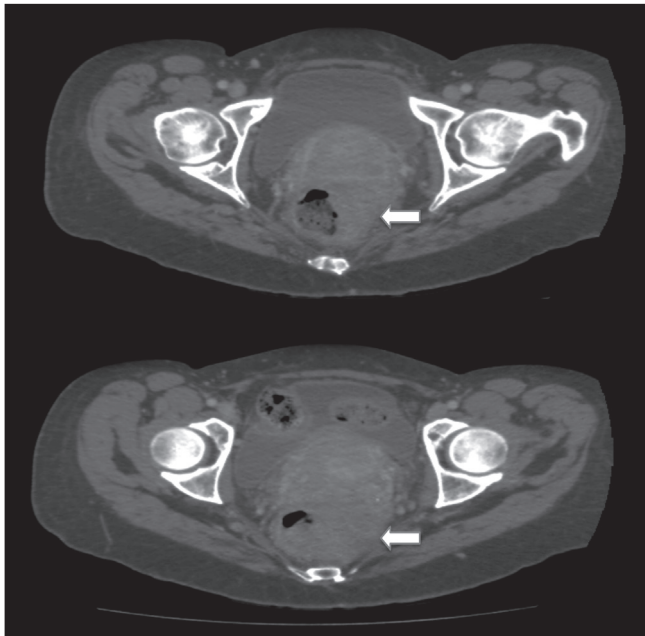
Pelvic computed tomography.
